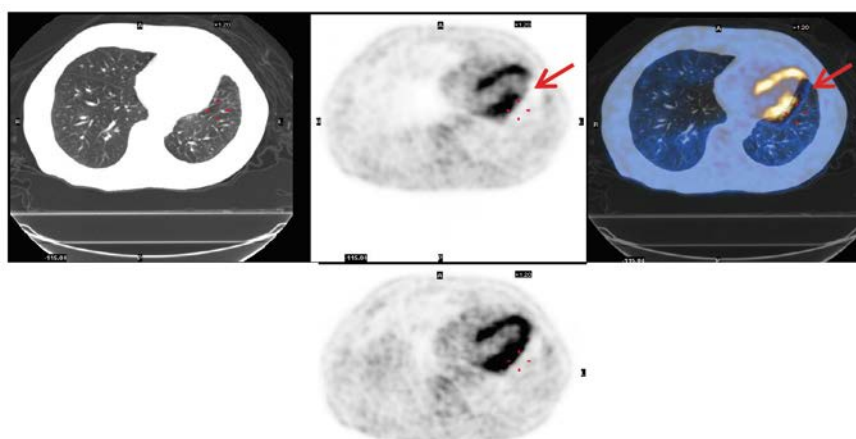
Top panel left to right: transaxial CT, PET and fused PET/CT images demonstrating the effects of misalignment (arrow) between PET and CT at the level of the heart. Bottom panel: PET image following proper alignment between PET and CT.
